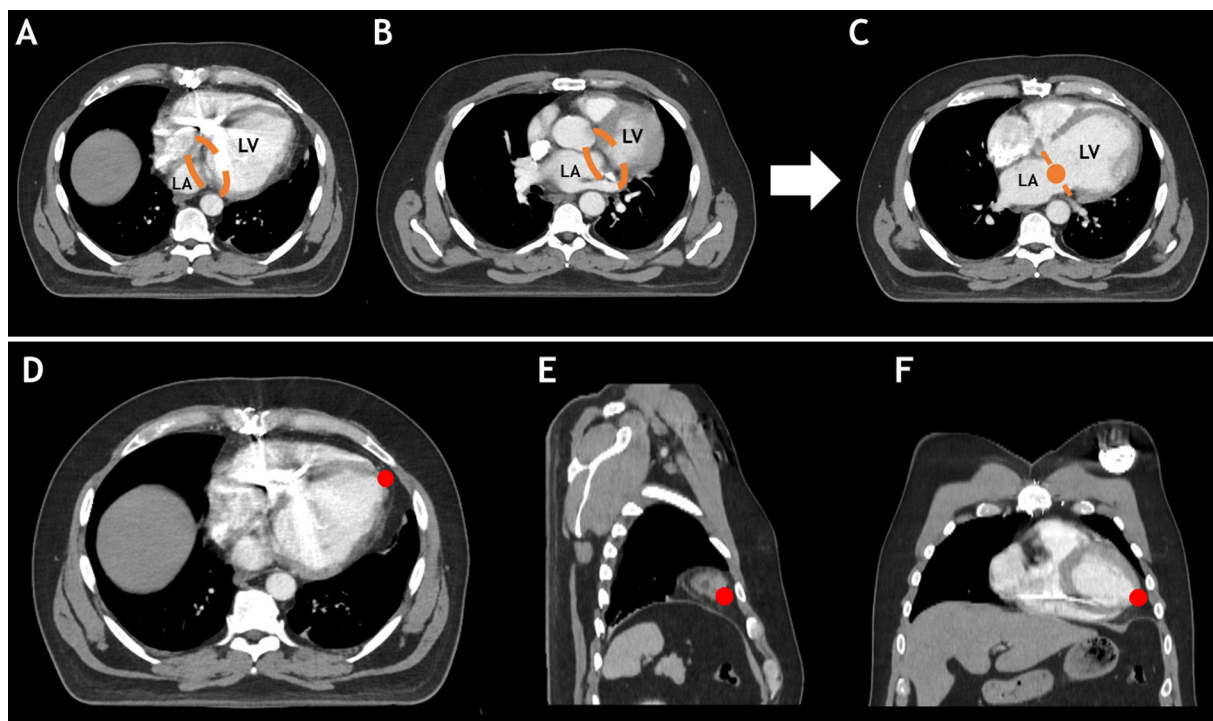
A computed tomography scan displaying the body in the planes perpendicular to the long axis of the body: axial plane (A, B, C, D), sagittal plane (E), and coronal plane (F). To set a marker in the center of the mitral valve plane, visualize the heart and identify a slice in which there is an “open” connection between the left atrium (LA) and left ventricle (LV). (A) Subsequently identify the inferior border of the mitral valve plane, this is defined as the first slice in which there is no ‘open’ connection between the LA and the LV (orange circle) (B) repeat this for the superior border of the mitral valve plane (orange circle). (C) Count the number of slices between the superior and inferior borders of the mitral valve plane and divide this number by 2. From inferior or superior, scroll the calculated number of slices up or down to determine the slice exactly in the middle of the mitral valve plane. Set a marker in the center of the mitral valve plane (orange dot). To set the apical marker (red dot), identify the most ventral and caudal part of the heart in the axial (D), sagittal (E), and coronal (F) planes.
